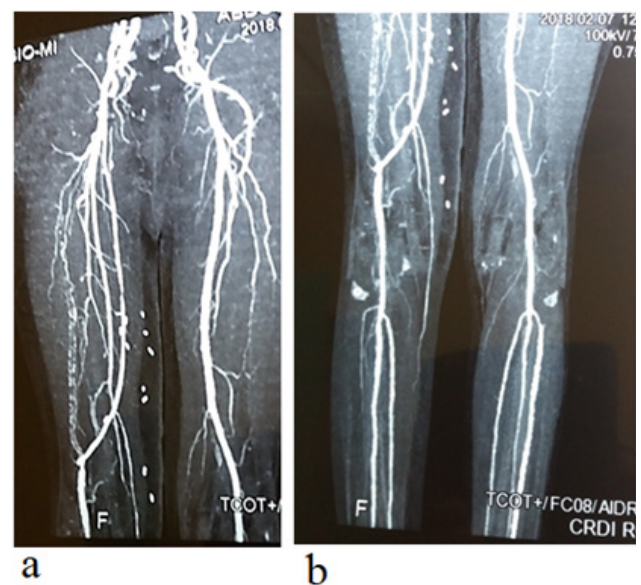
CT angiography control after femoro-popliteal bypass surgery, flattening and aneurysm.
